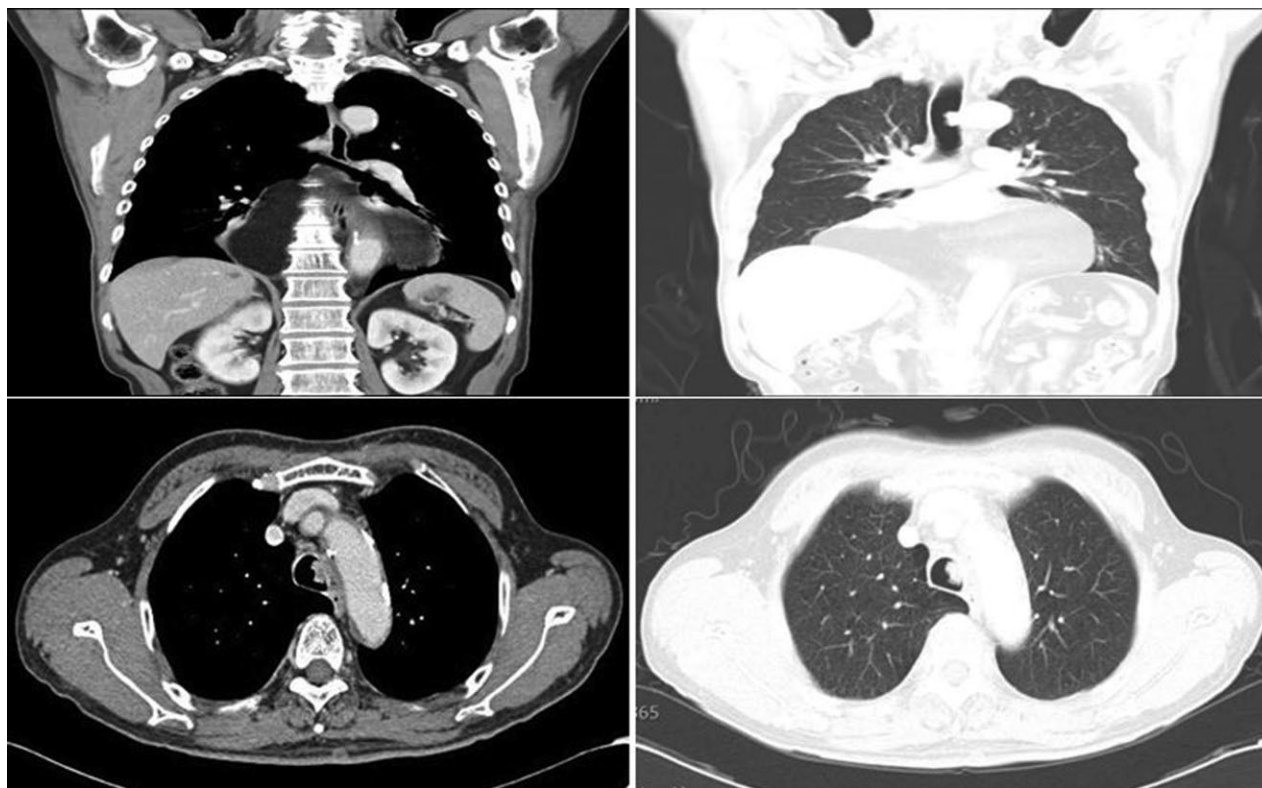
Chest computed tomography (CT) scans showing a tracheal nodule.
